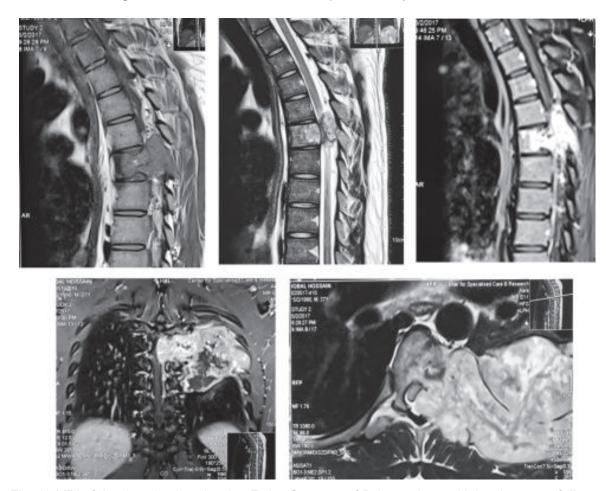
MRI of the dorsal spine showing Ewing Sarcoma of D-9 vertebrae with involvement of ribs.
